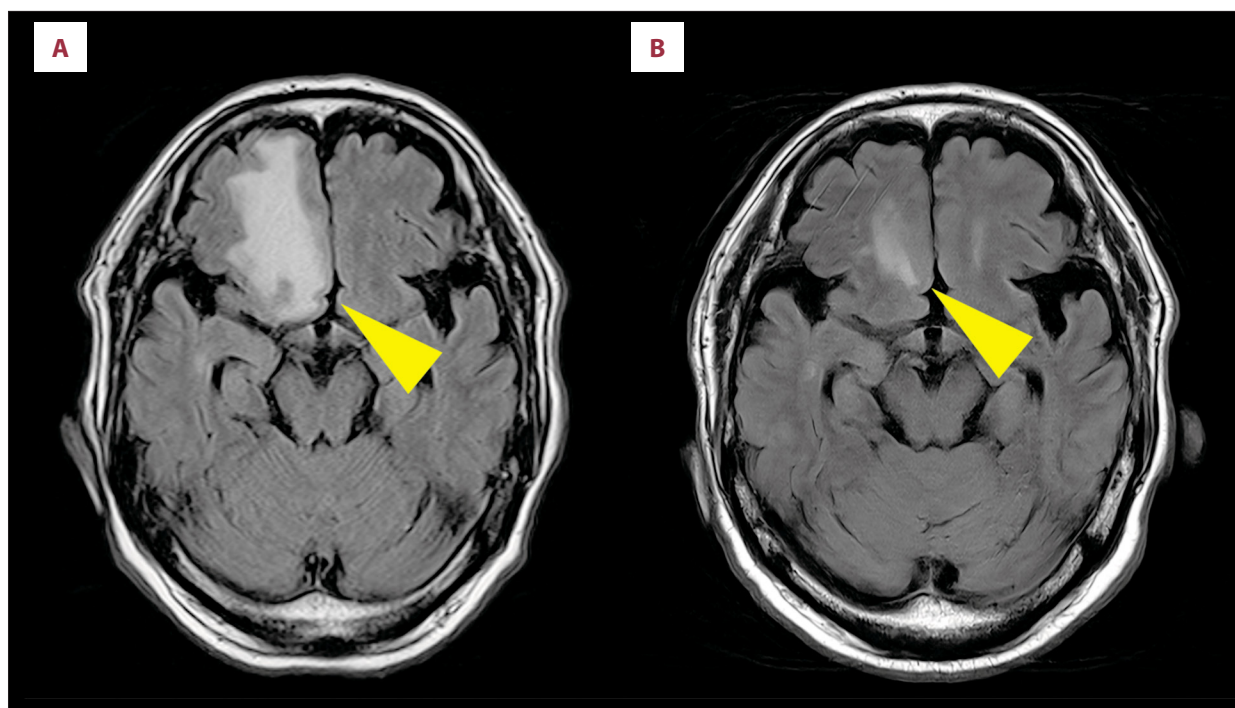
Brain magnetic resonance imaging before and after stereotactic body radiotherapy for isolated brain metastasis. (A) Axial fluid-attenuated inversion recovery (FLAIR) magnetic resonance imaging (MRI) showing a solitary hyperintense lesion in the left occipital lobe (arrow). Gadolinium contrast was not administered at diagnosis because of clinical considerations. (B) Follow-up axial FLAIR MRI after stereotactic radiotherapy (SRT) showing marked reduction in lesion size and good local control.
